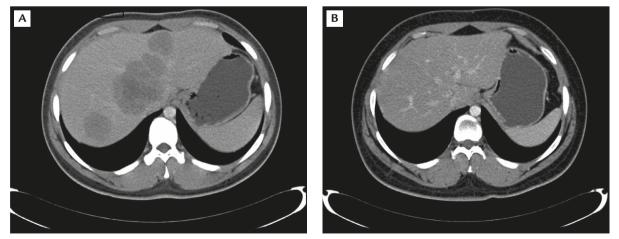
Computed tomography (CT) of the abdomen before and after treatment taken at the same level. (A) Initial CT taken on August 22, 2008 shows multiple liver metastases. (B) Recent CT taken on March 12, 2010 shows improvement.
